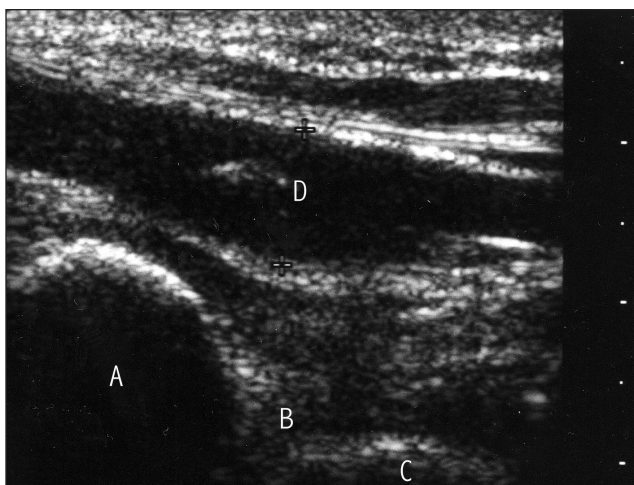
Transverse ultrasound imaging plane of the calcaneus. Region marked "A" is the medial calcaneal tubercle. Region marked "B" is the calcaneal sulcus. Region marked "C" is the lateral calcaneal tubercle. Region marked "D" is a band of plantar fascia.
